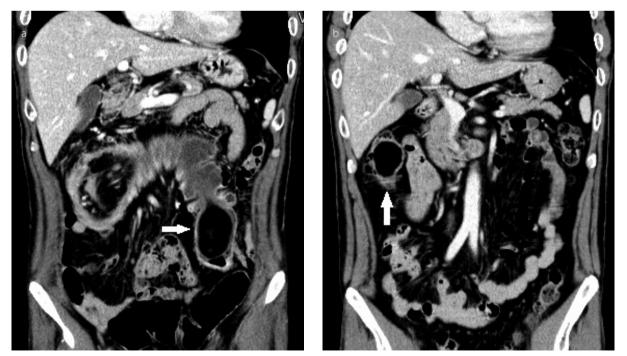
a, b. (a) Abdominopelvic computed tomography (CT) at admission showed a colonic intraluminal fatty mass with associated intussusception of the mesentery at the level of the distal transverse colon (arrow). (b) Abdominopelvic CT performed 2 years ago showed a colonic lipoma in the ascending colon (arrow)
